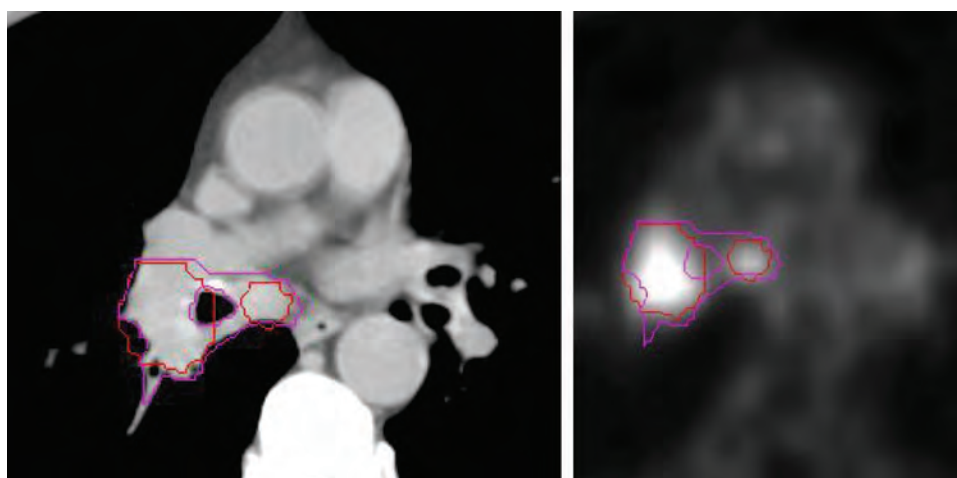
Gross tumor volume delineated on CT (left panel) using an automatic gradient-based delineation of the FDG-PET images (right panel). The GTV-T (FDG-PET, 0 Gy) and GTV-N (FDG-PET, 0 Gy) are displayed in red; the GTV T + N (FDG-PET + CT, 0 Gy) is displayed in pink in both panels.
